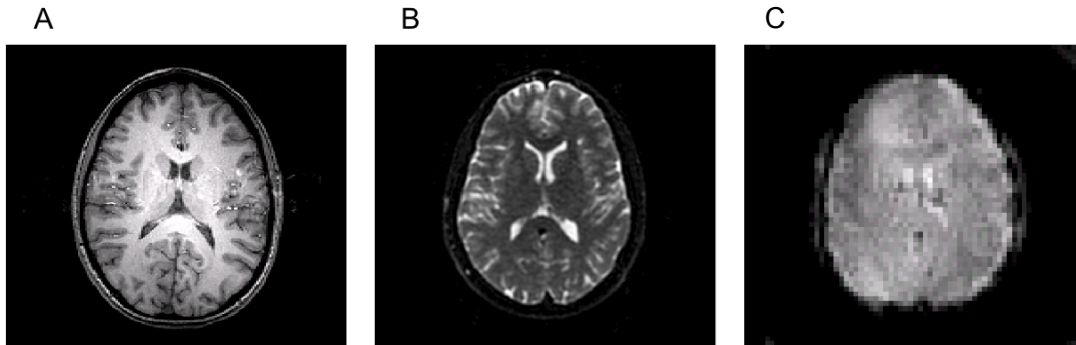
Examples of MRI images with different contrast. A: T1-weighted; B: T2-weighted; C: T2*-weighted (Mazerolle, unpublished results).
